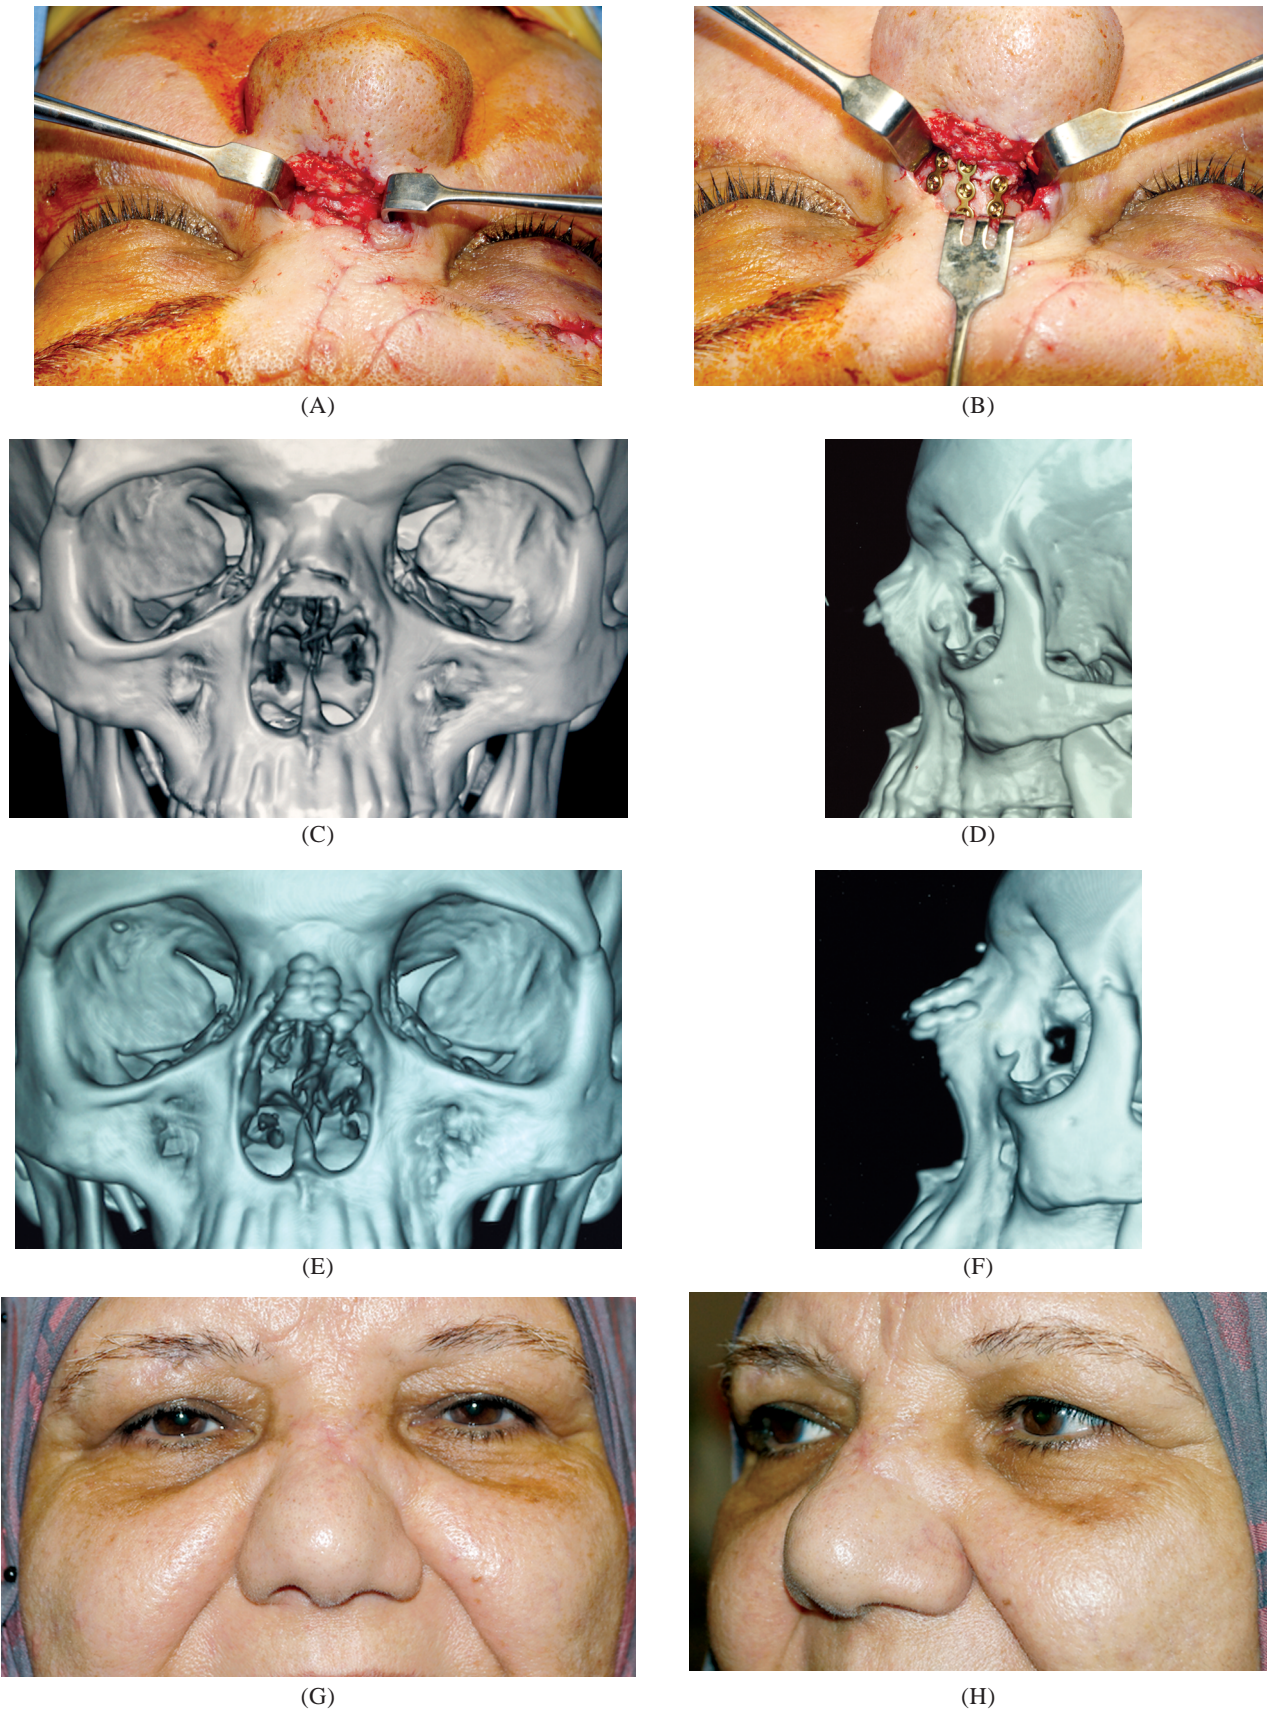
A 53 years old female patient who presented in a RTA with an open middle nasal fracture. (A&B) showing intra-operative exposure to the fracture and after fixation, (C&D) showing pre-operative 3D CT Scan of the Fracture, (E&F) showing post-operative 3D CT Scan after fixation with 1.2 microplates, (G&H) showing the same patient three months post-operatively, anterior and oblique views.
